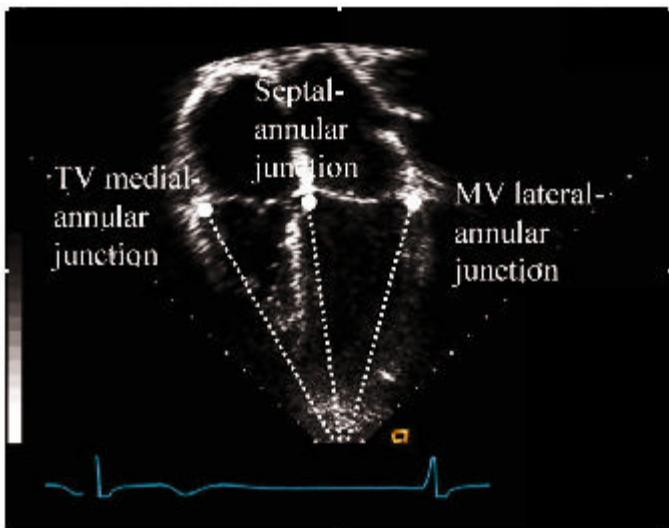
Apical 4 chamber image of Doppler sample volume position for pulsed Doppler tissue imaging analysis of longitudinal mitral and tricuspid annular motion. Assessment of annular motion can be obtained from the mitral valve (MV) lateral-annular junction, the septal-annular junction, and the tricuspid valve (TV) medial-annular junction. Cursor alignment from the apical window places the Doppler beam in the plane of maximal longitudinal annular motion.
